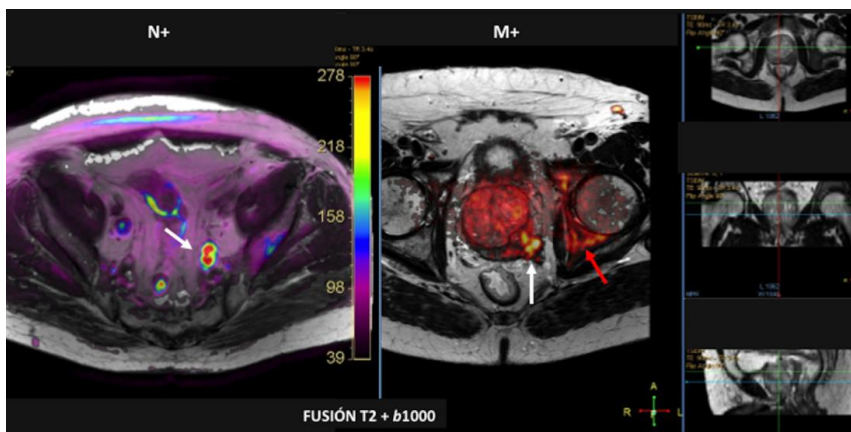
Pelvic MRI on T2 sequence. Patient with suspected prostate carcinoma (PSA 18). Pelvic MRI on T2 sequence shows a neoplasm invading the neurovascular left band (white arrow) and alteration of the bone signal (red arrows).
